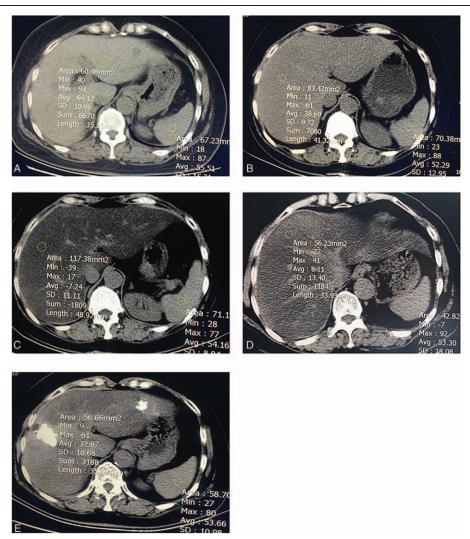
(A) The liver-to-spleen CT ratio (L/S ratio) of 1.16 (64.13/55.51) upon the onset of CAP regimen. (B) The liver-to-spleen CT ratio (L/S ratio) of 0.74 (38.69/ 52.29) after a 3-cycle course with CAP. (C) The L/S ratio of -0.13 (-7.24/54.16) after a 10-cycle course with CAP. (D) The L/S ratio returned to 0.15 (8.11/53.3) after 5 months withdrawal. (E) The L/S ratio of 0.61 (32.87/53.66) after 12 months withdrawal.
